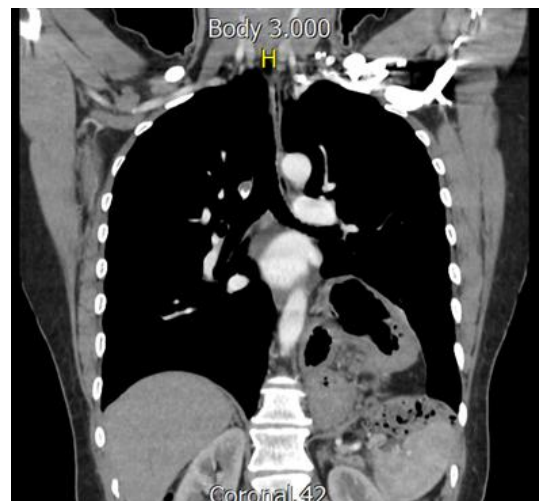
Computed tomography (CT) of the chest with and without contrast, axial section, demonstrating the presence of abdominal organs within the thoracic cavity.
